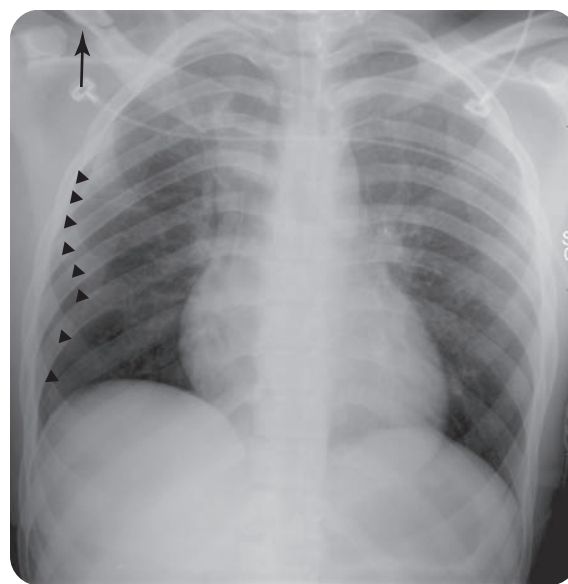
A portable chest radiograph in a trauma patient, demonstrating an acute right clavicle fracture (arrow) associated with a moderate-sized right pneumothorax (arrowheads). A computed tomography scan of the chest demonstrated nondisplaced fractures of the right ribs.
